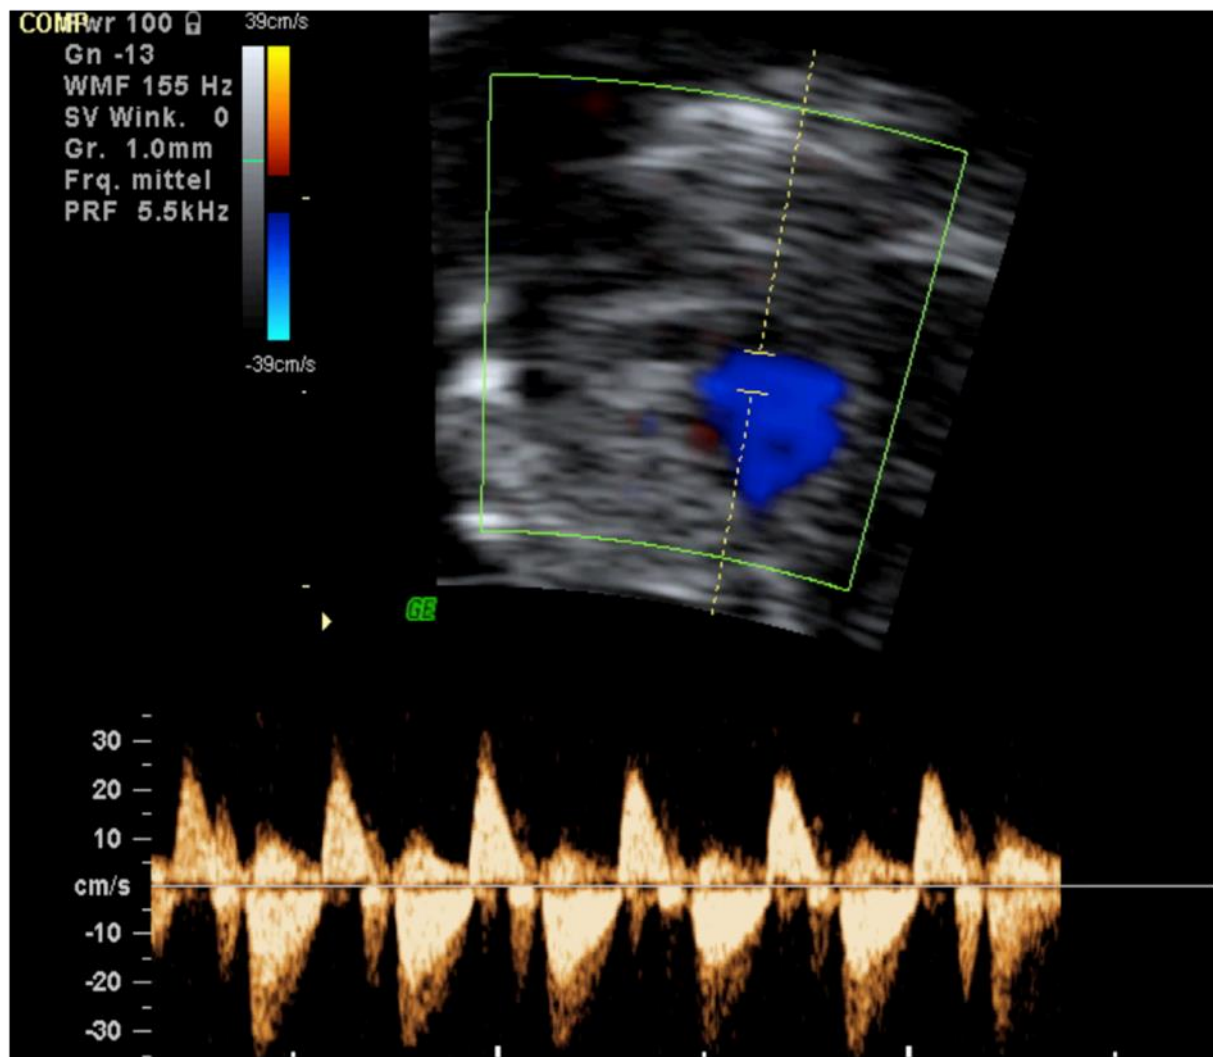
Blood flow across pulmonary fibrous annulus in fetus of 13 weeks of gestation with TOF/APVS. Continuous wave Doppler recording demonstrates pulmonary to-and-fro-flow.
